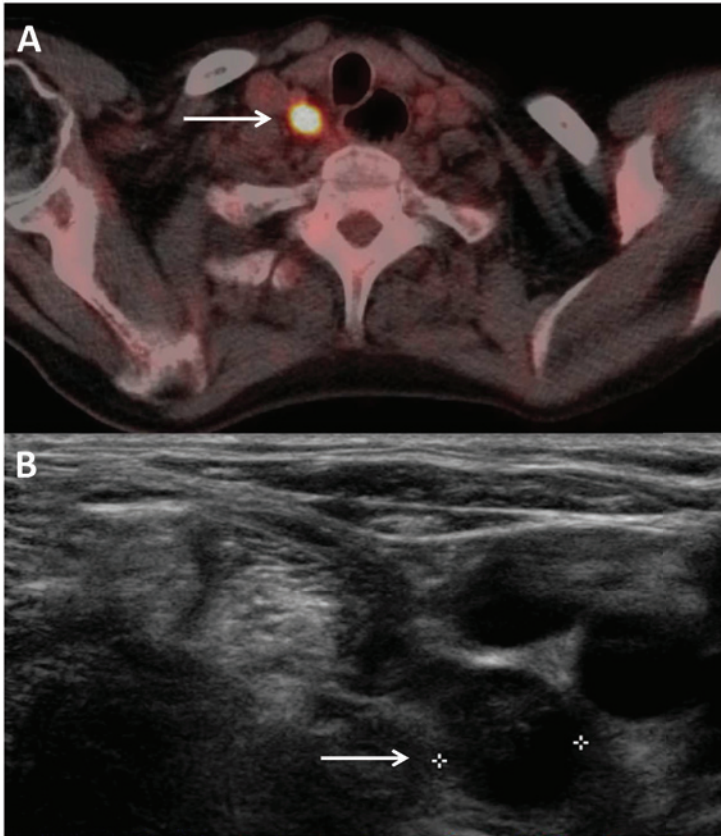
A. Fused axial PET/CT image demonstrating a 10 mm FDG avid cervical lymph lymphnode metastasis in station IV (right) during initial staging in a patient with a primary esophageal squamous cell tumor (arrow). B. Cervical ultrasonography image in the same patient, demonstrating a 10 mm cervical round-shaped lymph node metastasis in level IV (right). The cervical lymph node was confirmed malignant with FNA (arrow).
